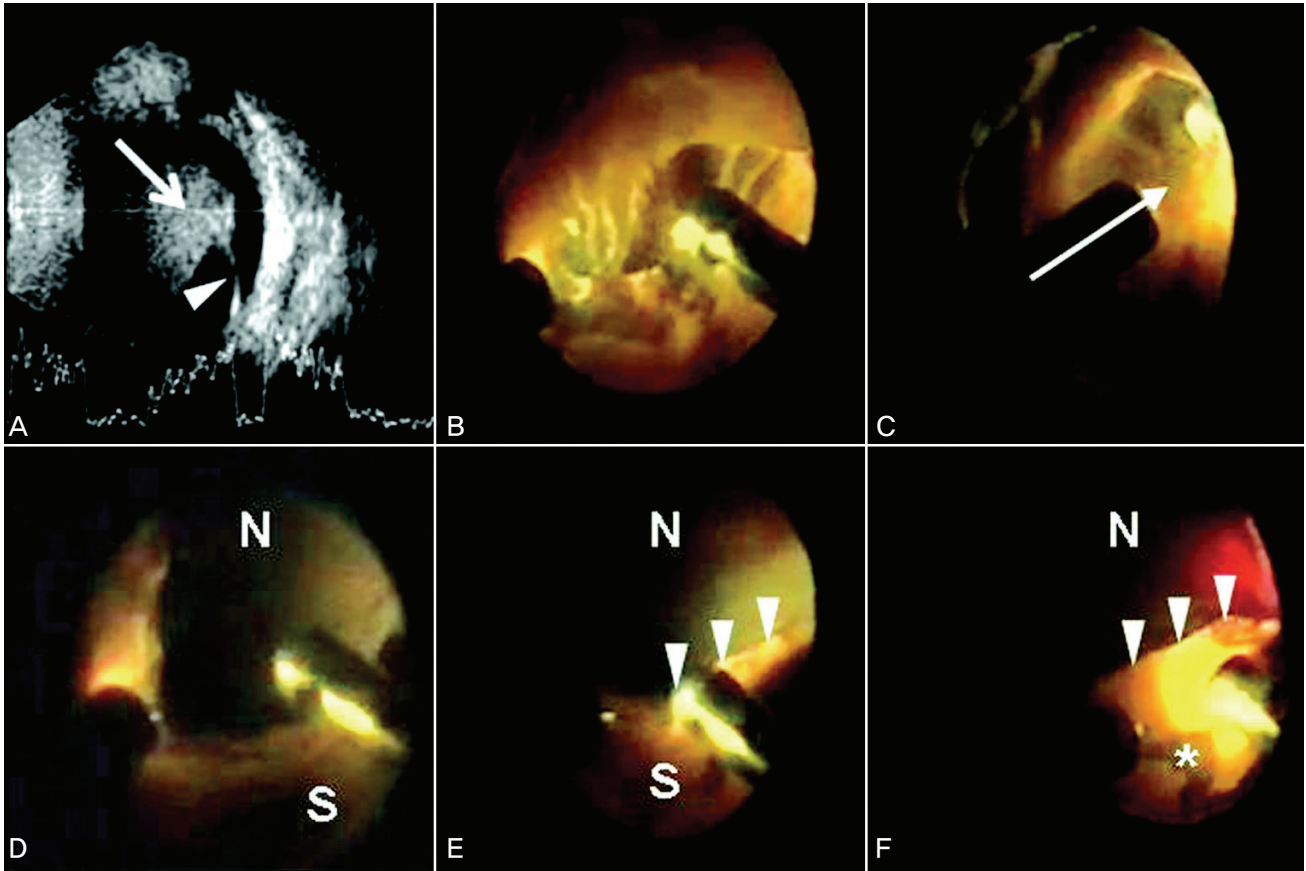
Preoperative ultrasonography (USG) and intraoperative fundus findings of the right eye in case 1. USG shows vitreous hemorrhage (arrow) and suggests retinoschisis (arrowhead) (A). Massive vitreous hemorrhage is being removed after lensectomy (B). Thin membranous structure (arrow) is detected during careful vitrectomy (C). After excision of thin membranous inner layer, nonschisis retina (N) can be shown (D). The stump (arrowheads) of inner layer can be shown with adherent intraschisis blood clot (E). As intraschisis blood is being removed, the outer layer (star) of the schisis retina (S) appears (F).
